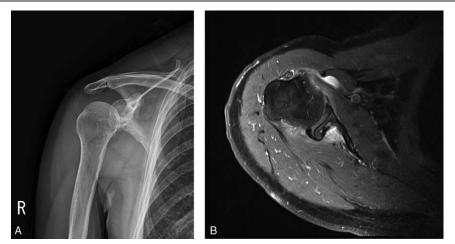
Follow-up radiograph and magnetic resonance imaging (MRI) obtained 18 months after excision. Plain radiograph and fat-suppressed T2-weighted axial imaging show complete decompression of the cystic lesion with no recurrence.
